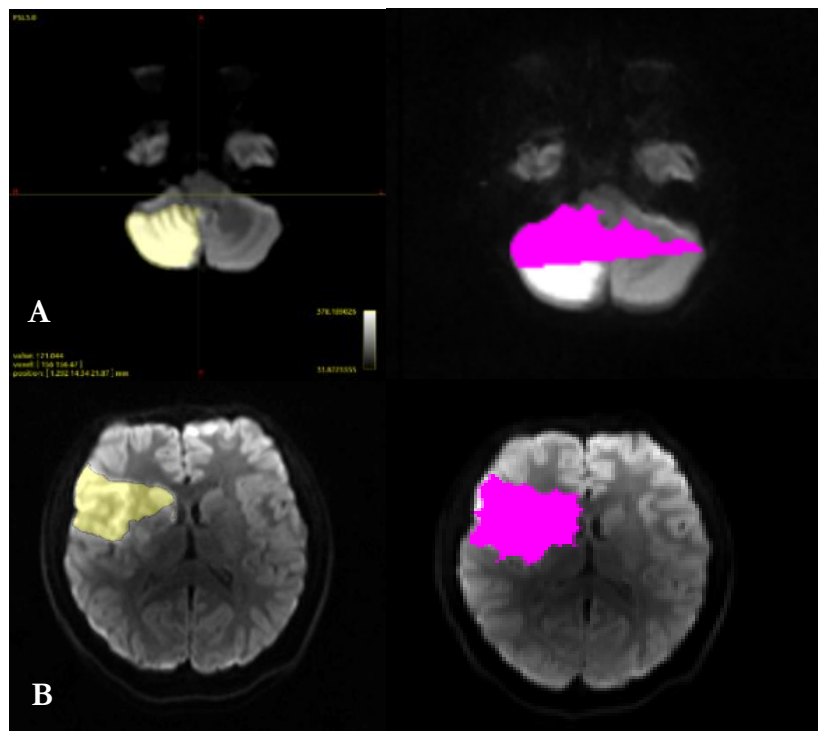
Two cases with suboptimal RAPID DWI segmentation. A – Cerebellar stroke, missing some and over-including other infarcted tissue. B – Overinclusion of infarcted tissue
